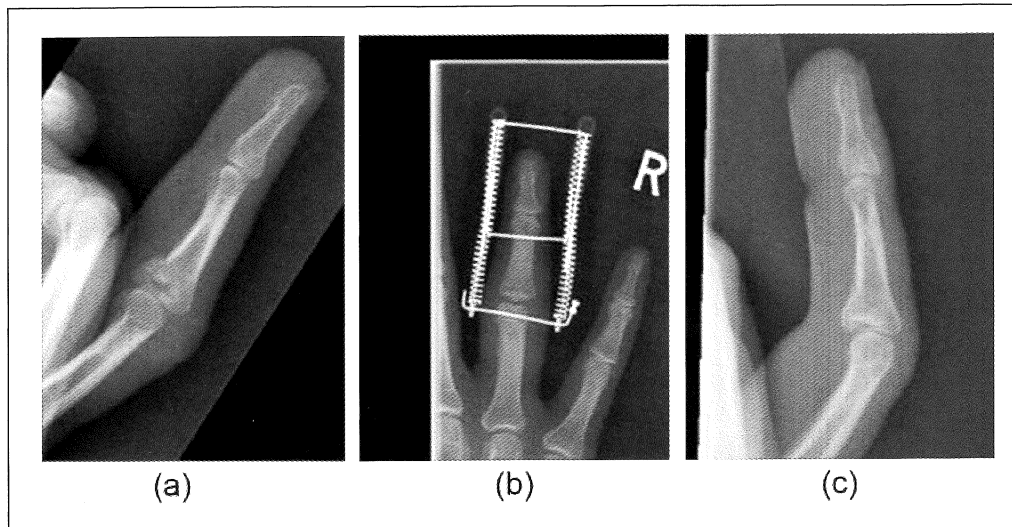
(a) A fracture-subluxation of the PIPJ suitable for dynamic traction with the *Ligamentotaxor*. (b) Postoperative radiograph with the device in situ. (c) Final outcome at 3 months (QuickDASH score = 0).
